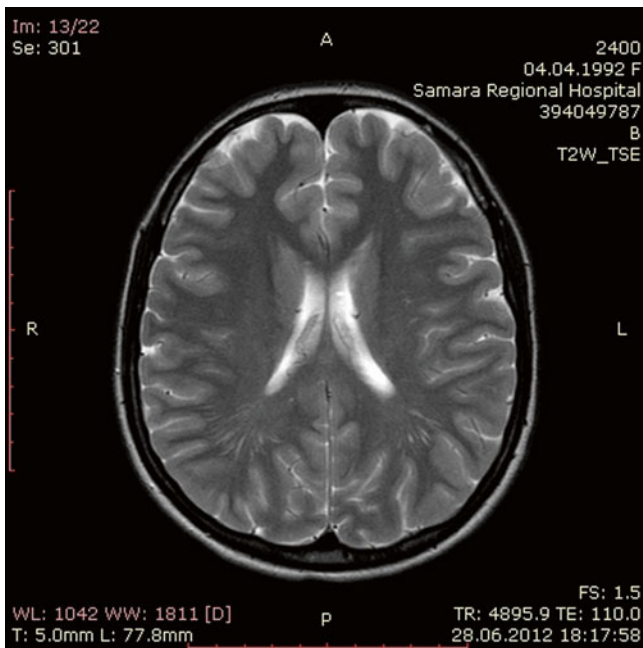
Axial T2-weighted MRI in a 20-year-old female patient, with remote consequences of perinatal hypoxic–ischemic brain injury (HI-BI), current encephalopathy, and numerous linear ventricular system (VS)-focused white matter (WM)-PVA in the posterior brain parts. Magnification $\times 400$
